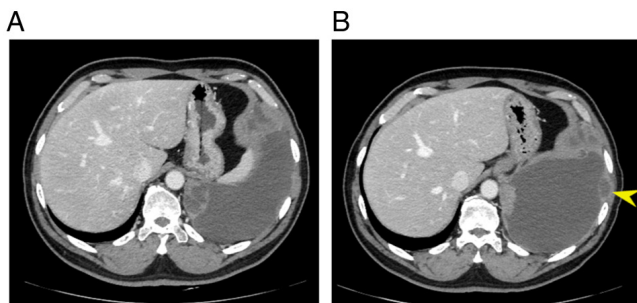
Computed tomography imaging of the left metastatic lung and pleural lesions. The left metastatic pleural lesions have shrunk slightly and newly developed (yellow arrowhead) between the period (A) before start of trabectedin monotherapy and (B) after 18 cycles of trabectedin monotherapy. An increase in pleural effusion was observed.
